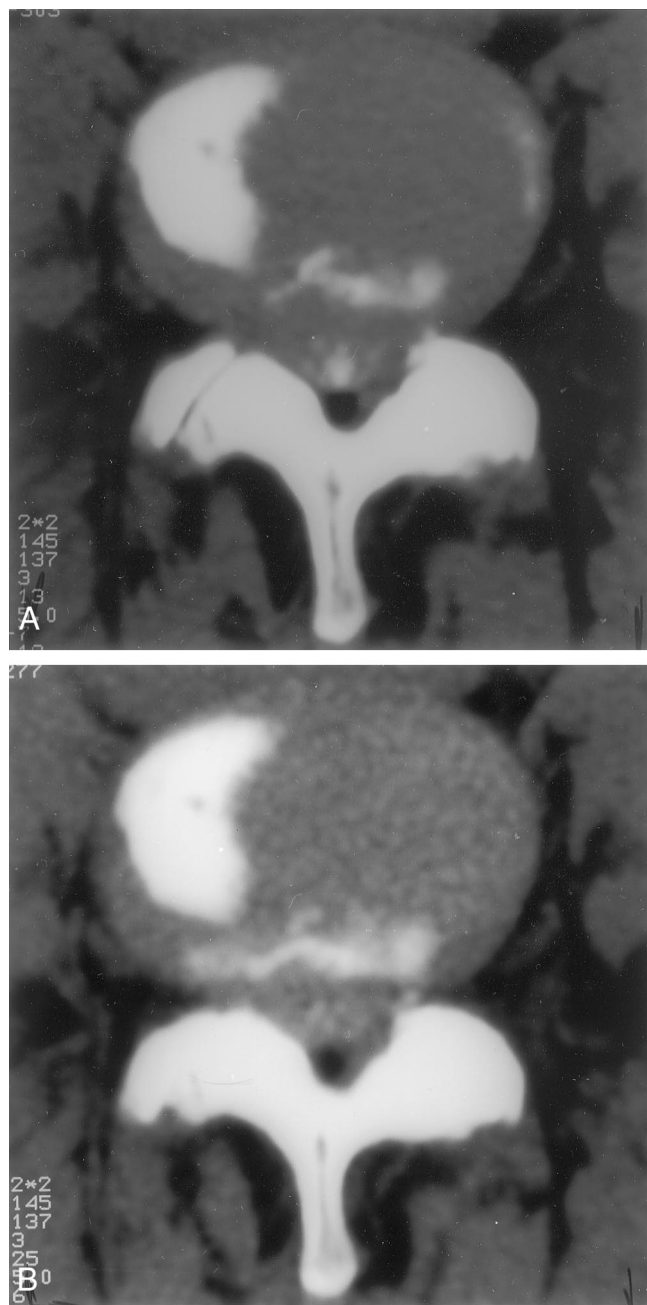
Patient 40. Computed tomography (CT) myelographic images of L4–L5 in a 44-year-old woman with a 1-year history of pain and impaired motor and sensory function in her legs when walking less than 100 m. The cross-sectional area of the dural sac in disc level decreased significantly to an indisputable stenosis from (A) relaxed position (PRP) to (B) axially loaded position (ACE). After decompression and fusion, her leg pain disappeared, and at this writing, she has been back at work full-time for 3 years.
